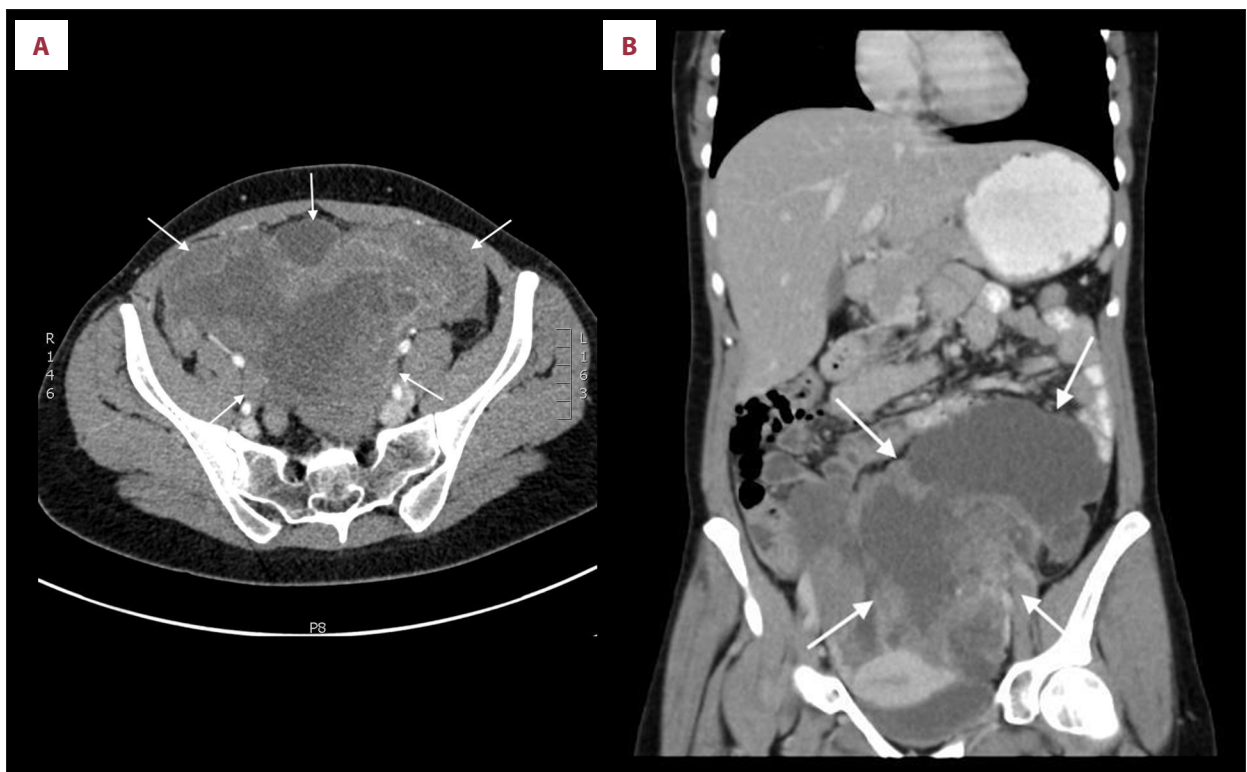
Computed tomography scan showing a left ovarian tumor (white arrows) with the size of 20×20×19 cm: (A) axial view and (B) coronal view.
